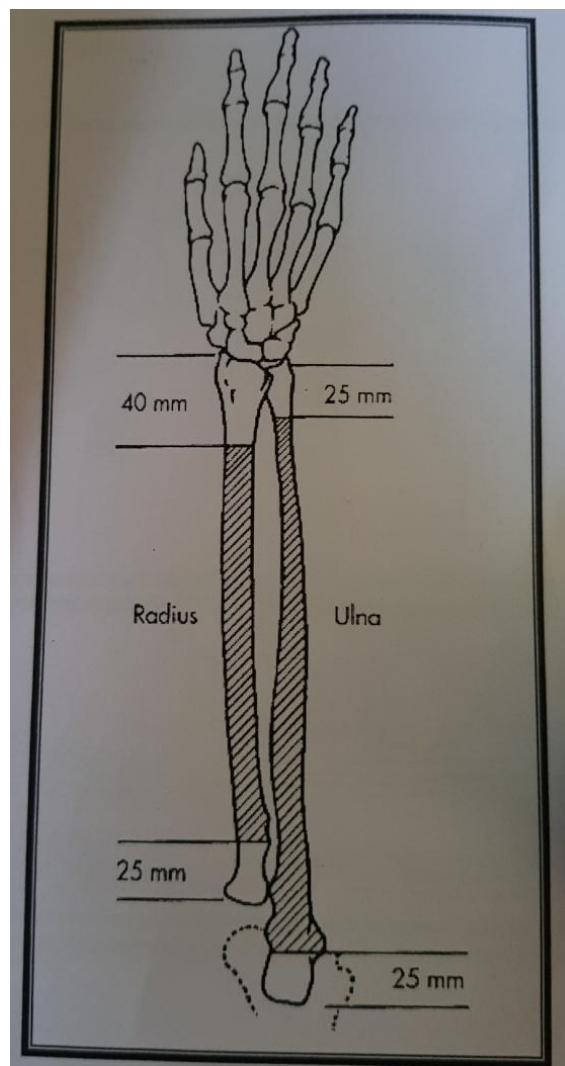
Area over Diaphysis where intramedullary nailing can be done Preoperative evaluation of nail length is done with X-Rays of normal side.
